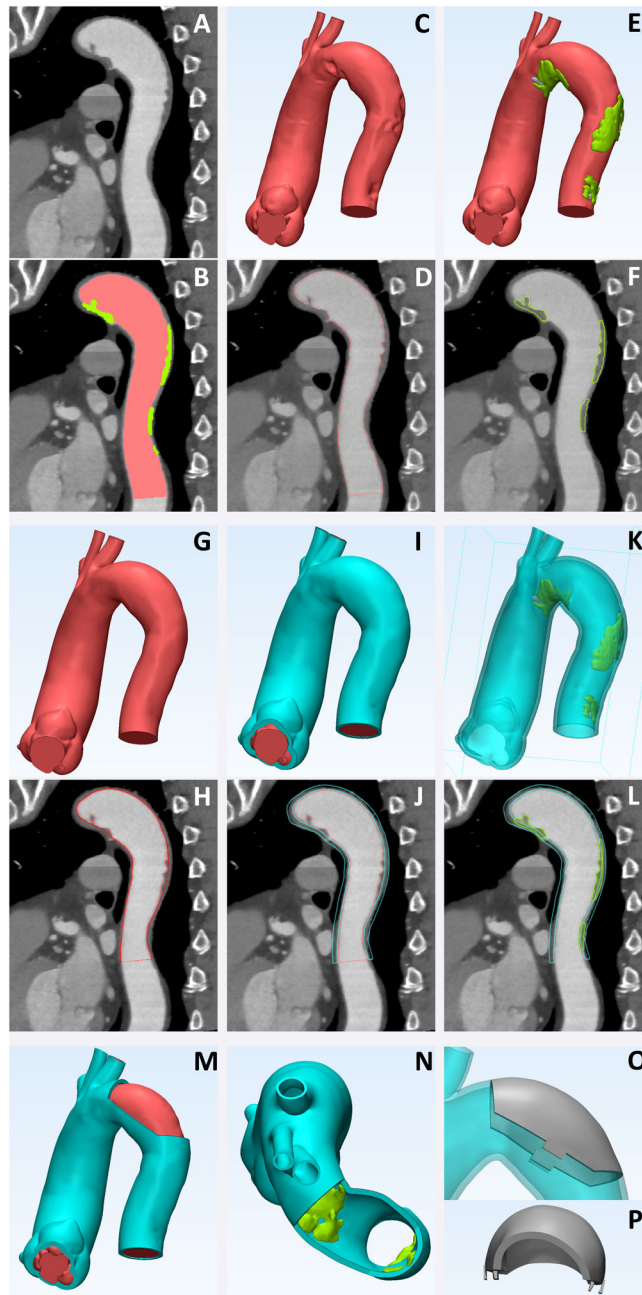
Complete sequence of STL generation and CAD manipulations to produce a model for planning of an endovascular procedure in an aorta with mural thrombi from contrast-enhanced CTA
